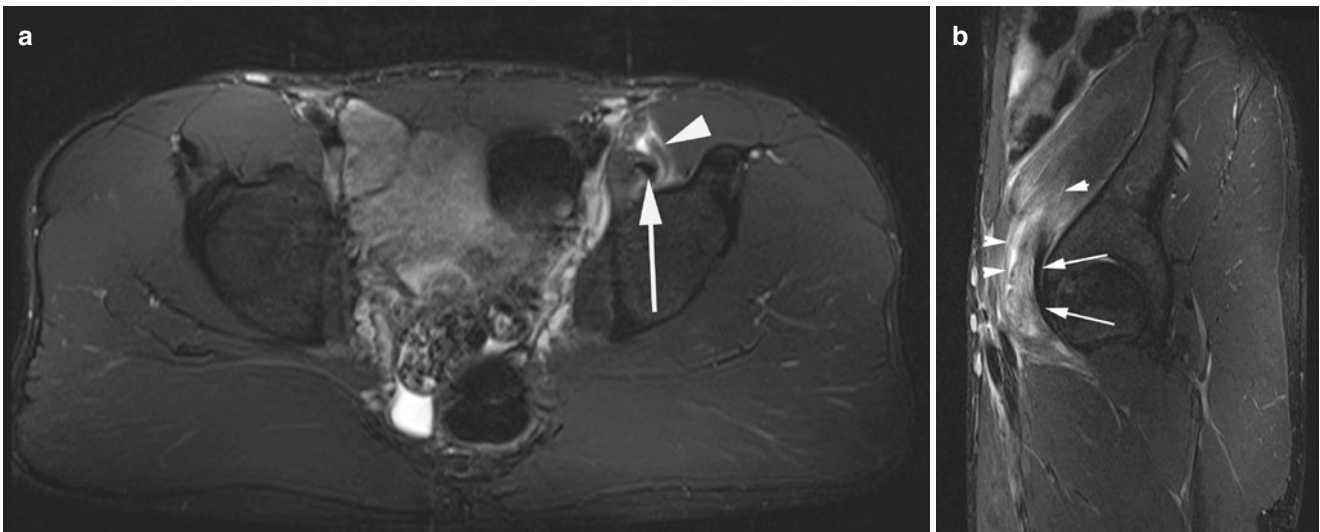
Myotendinous injury. A 21-year-old soccer player with acute anterior hip pain. (a) Axial and (b) sagittal T2FS MR images show intact psoas major tendon (arrow) and myotendinous iliacus injury (arrowhead)
